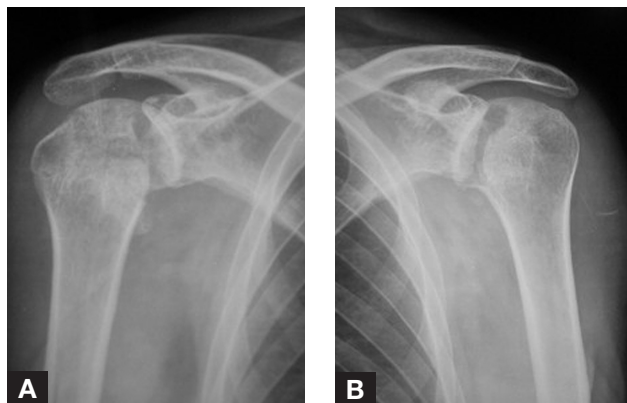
Anteroposterior x-ray of the left (A) and the right (B) shoulders showing bilateral posterior dislocation.
